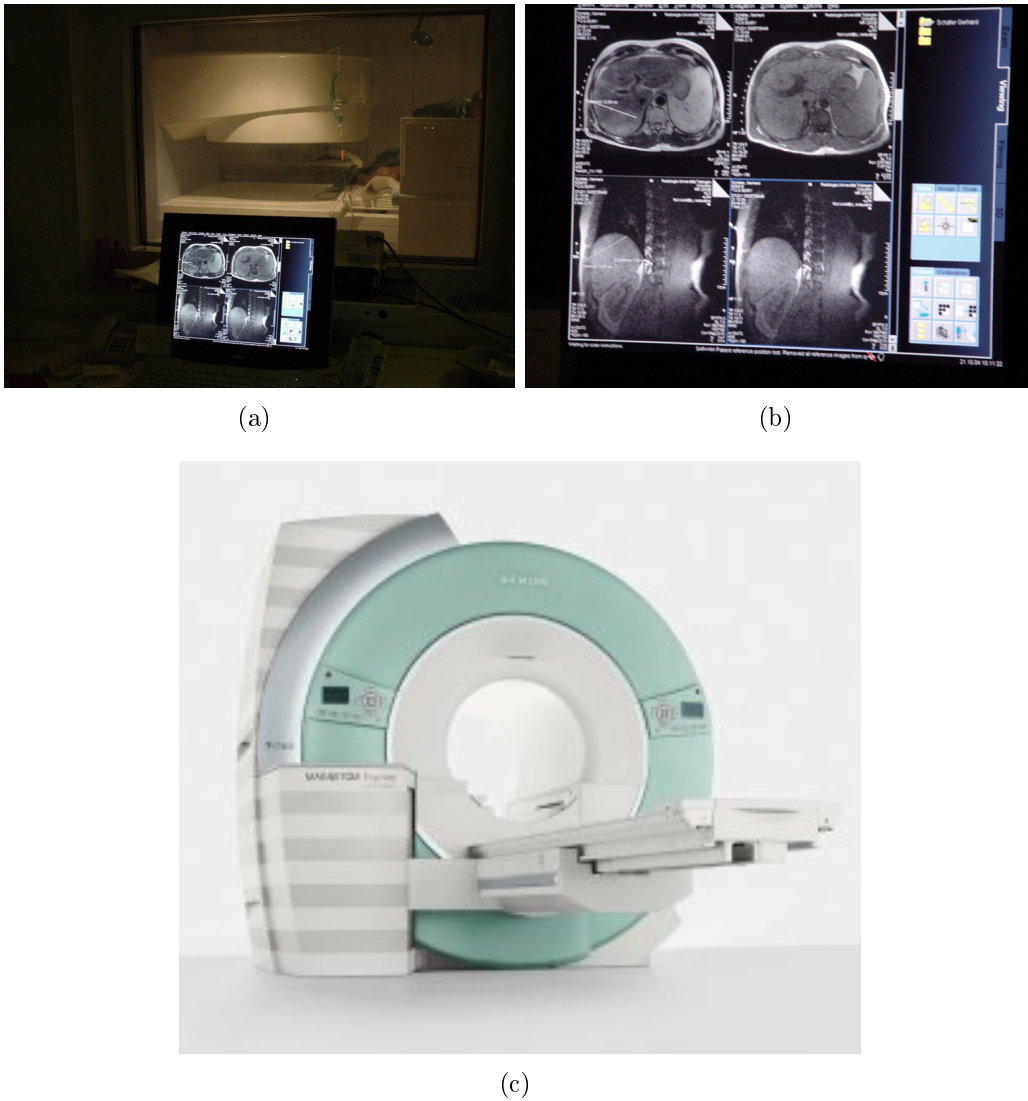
Setup of an intervention under iMRI guidance. (a) Magnetom Open, Siemens Medical Solutions, Erlangen, Germany. The MR scanner has an open magnet design where the access to the patient is from the side. (b) Planning on the workstation for trajectory path. (c) Magnetom Espree, Siemens Medical Solutions. New generation of MRI machine with a bigger bore to enable better patient access.
